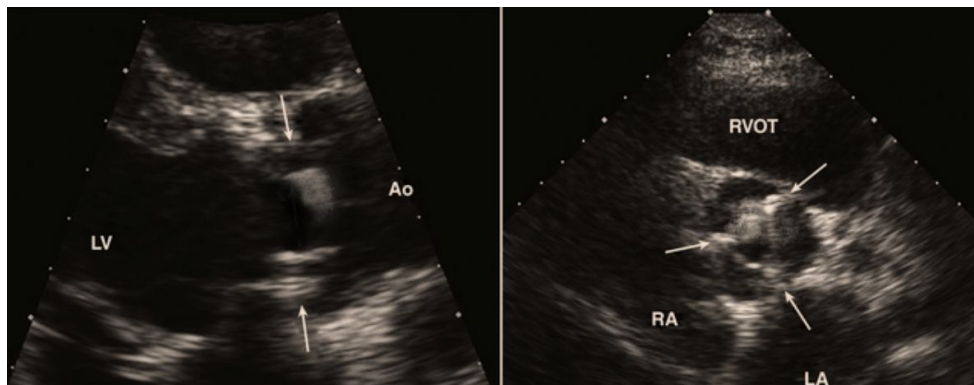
parasternal long and short axis showing the image of vegetation of the aortic mechanical valve
